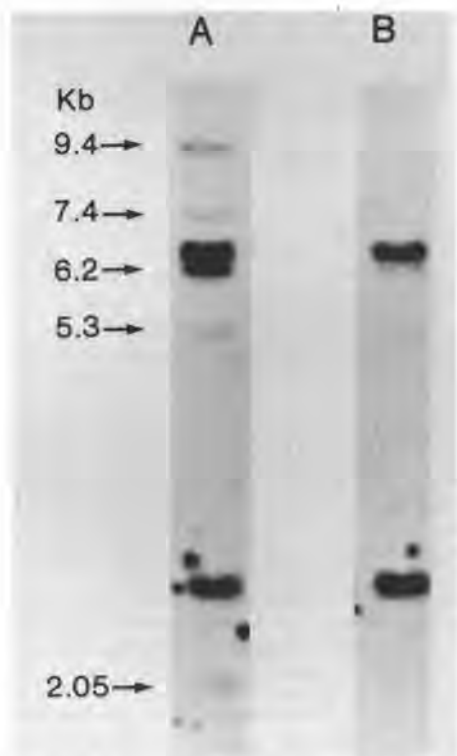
Southern blot analysis of control DNA (lane A) and endometrioid carcinoma of low malignant potential (lane B) using a probe to the *RB* gene and a probe to monitor DNA transfer. The intensity of the band monitoring the amount of DNA on the filter (two intense bands in this figure) was nearly identical in the control and tumor tissues. Compared with the control tissue in lane A, the 9.4-kb and 7.4-kb bands detected by the probe to the *RB* gene were deleted in lane B. (Sasano H, Comerford J, Silverberg SG, Garrett CT: Analysis of abnormalities of the retinoblastoma gene in human ovarian and endometrial carcinoma. *Cancer* 66:2150-2154, 1990)
